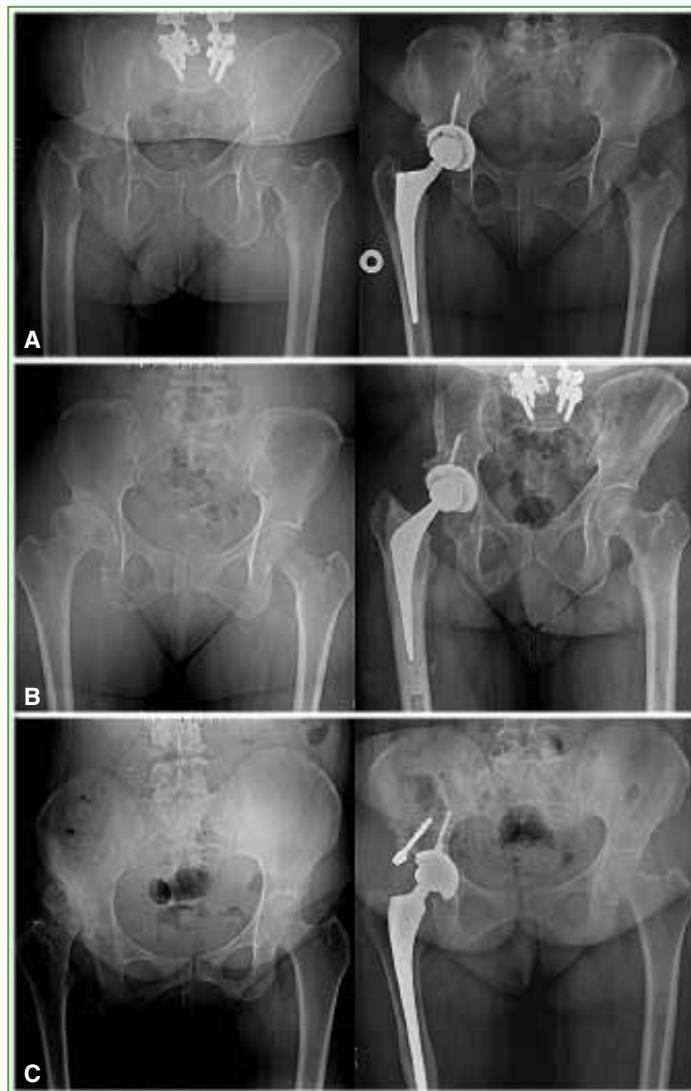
Preoperative (left column) and postoperative (right column) radiographs according to acetabular management technique: medialization (A), high hip center (B), and bone grafting (C).
